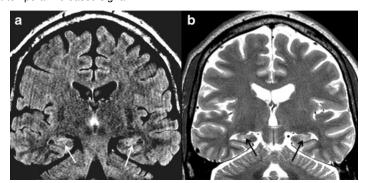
27 y/o F with recurrent partial complex seizures. MRI showing bilateral hippopcampal atrophy and increased T2/FLAIR signal indicative of bilateral mesial temporal sclerosis.
